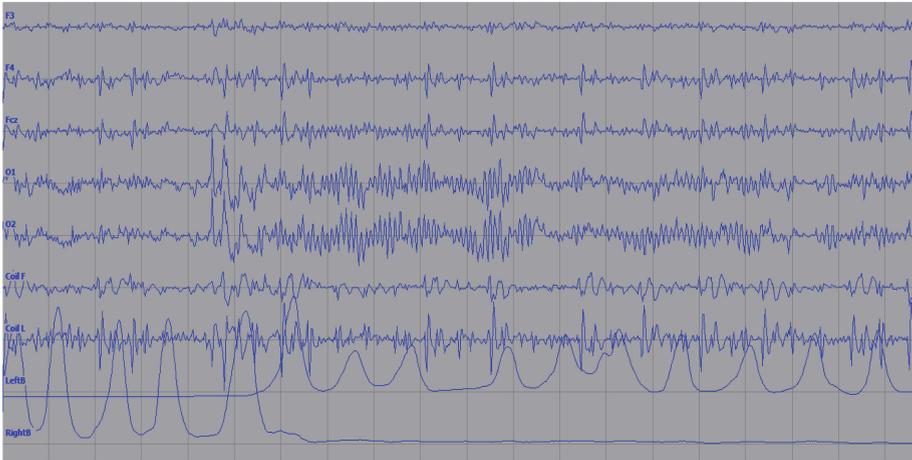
Alpha-rhythm of EEG in waking state (after MRI gradient and cardioballistic artifact correction).
